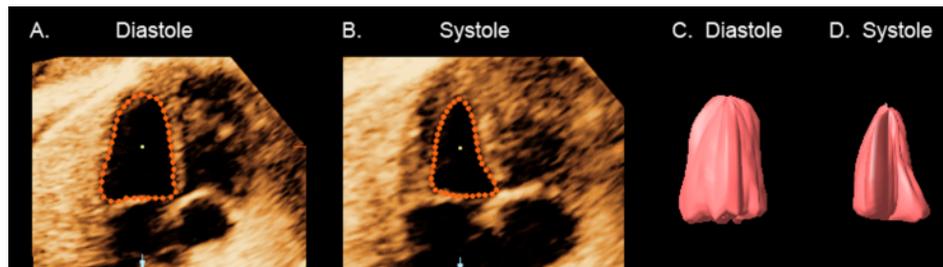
Three-dimensional ultrasound images of the left ventricle in diastole (A) and systole (B), and the cardiac volumes obtained from them using VOCAL™ (Virtual Organ Computer-aided AnaLysis) (C and D, respectively).
